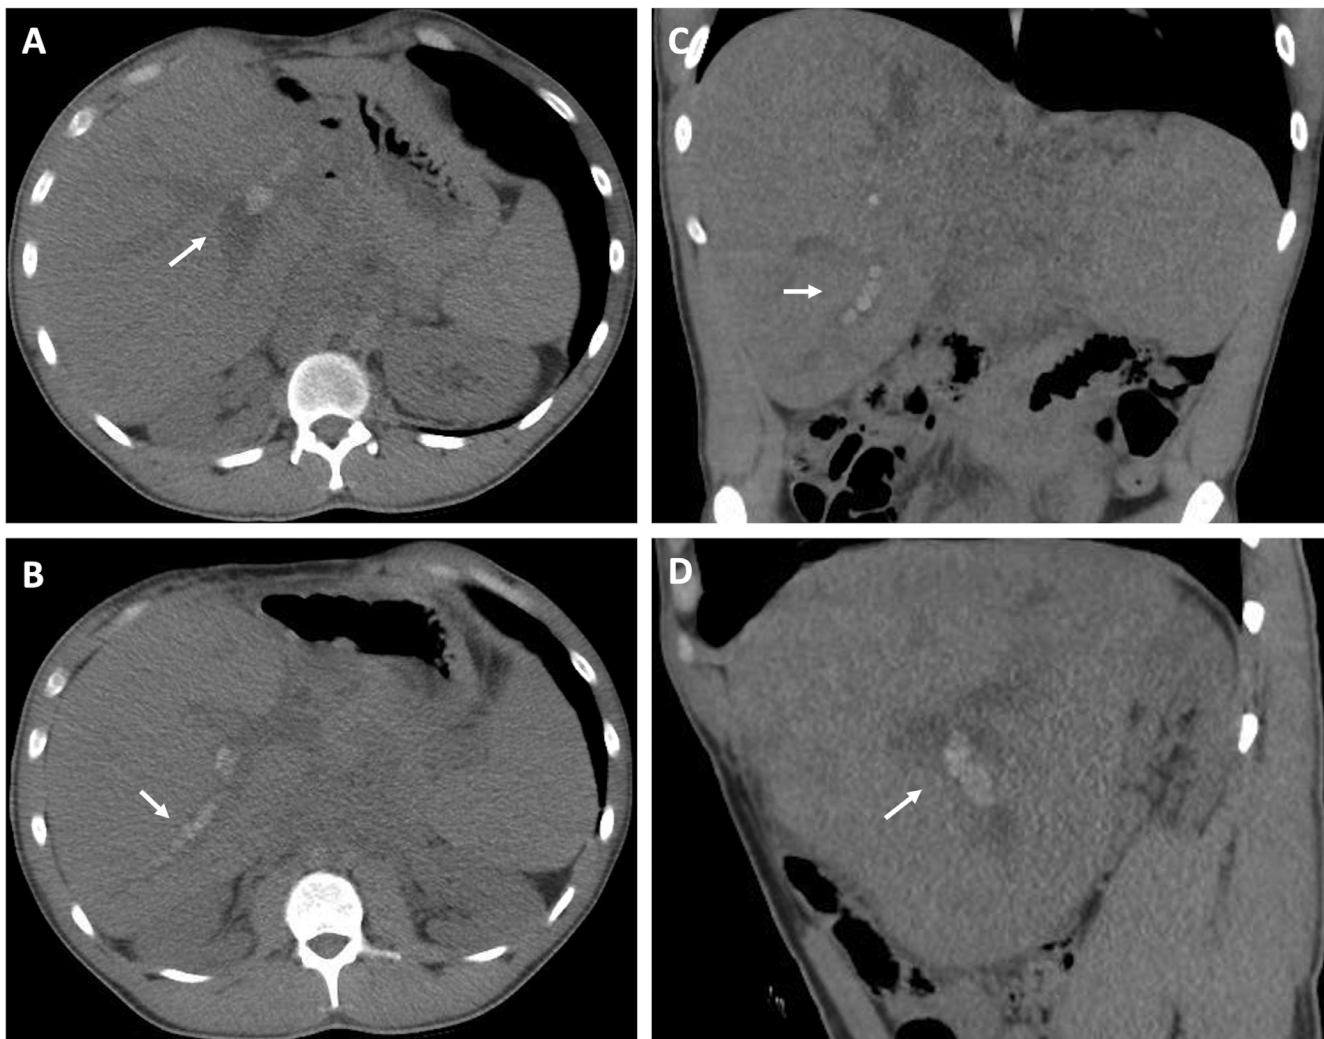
CT abdomen and pelvic on the day of presentation. Axial (A and B), coronal (C), and sagittal (D) views. Extensive hyperdensities (white arrows) within tubular structures on this noncontrast CT in this post liver transplant and recent postliver biopsy may represent; blood in the bile duct, biliary calculi or possibly venous thrombosis.
